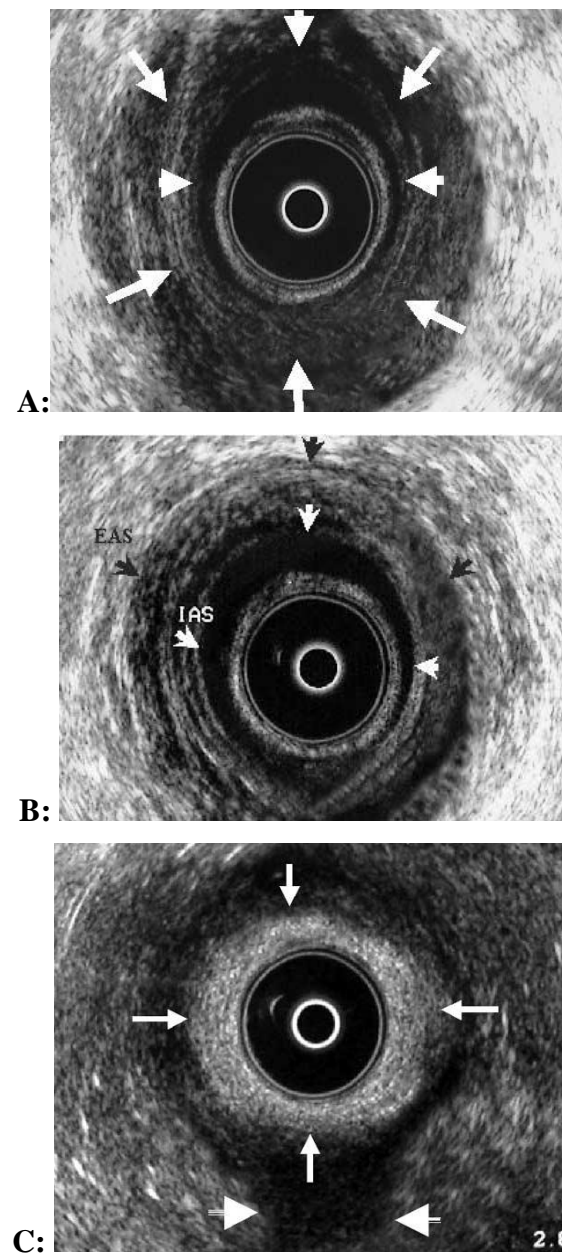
Normal endoanal sonographic appearances of anal sphincters at 3 different levels. A, Upper anal canal level, identified by the horseshoe sling of the puborectalis muscle posteriorly (arrows) and loss of the EAS in the midline anteriorly. The IAS is also shown by arrowheads. B, Middle canal level, identified by the completion of the EAS ring anteriorly (black arrows) and maximum IAS thickness (white arrows). C, Lower canal level, defined as that immediately caudal to the termination of the IAS and comprising the subcutaneous the EAS (arrows). The anococcygeal ligament is also shown posteriorly (arrowheads) (*Engin, 2006*).
